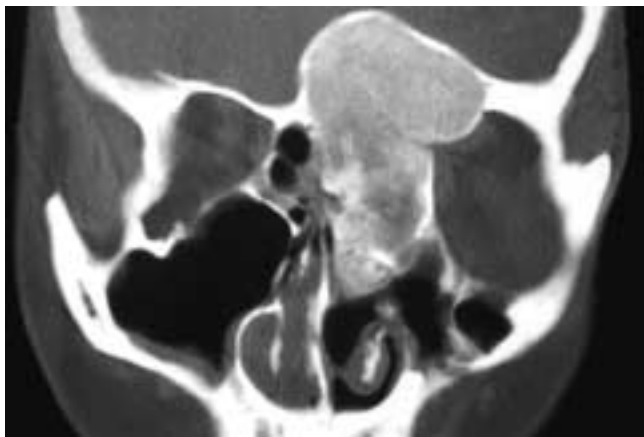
Coronal CT scan shows a localized region of expanded bone in the left frontal and ethmoid bone. The medullary space has a "ground glass" appearance, and the cortices are intact. This patient had fibrous dysplasia.
